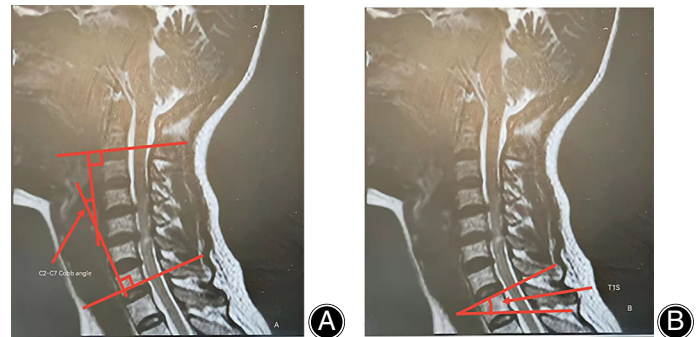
The sagittal, T2-weighted magnetic resonance image of the cervical spine. (A) The measurement of the C2–C7 Cobb angle: the angle between the C2 inferior endplate and C7 inferior endplate. The measured sagittal parameters of cervical spine included: 1. C2–C7 Cobb angle: the angle between C2 inferior endplate and C7 inferior endplate; (B) The measurement of the T1S: the angle between the superior endplate of T1 and the horizontal. T1S: the angle between superior endplate of T1 and horizontal.
